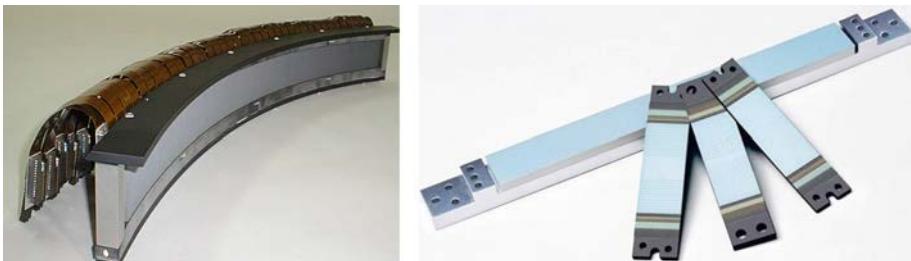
Detector modules for a 4, 16, 64 and 320 slice CT scanner (left). The complete CT detector is composed of many detector modules (right) (courtesy Toshiba Medical Systems).
